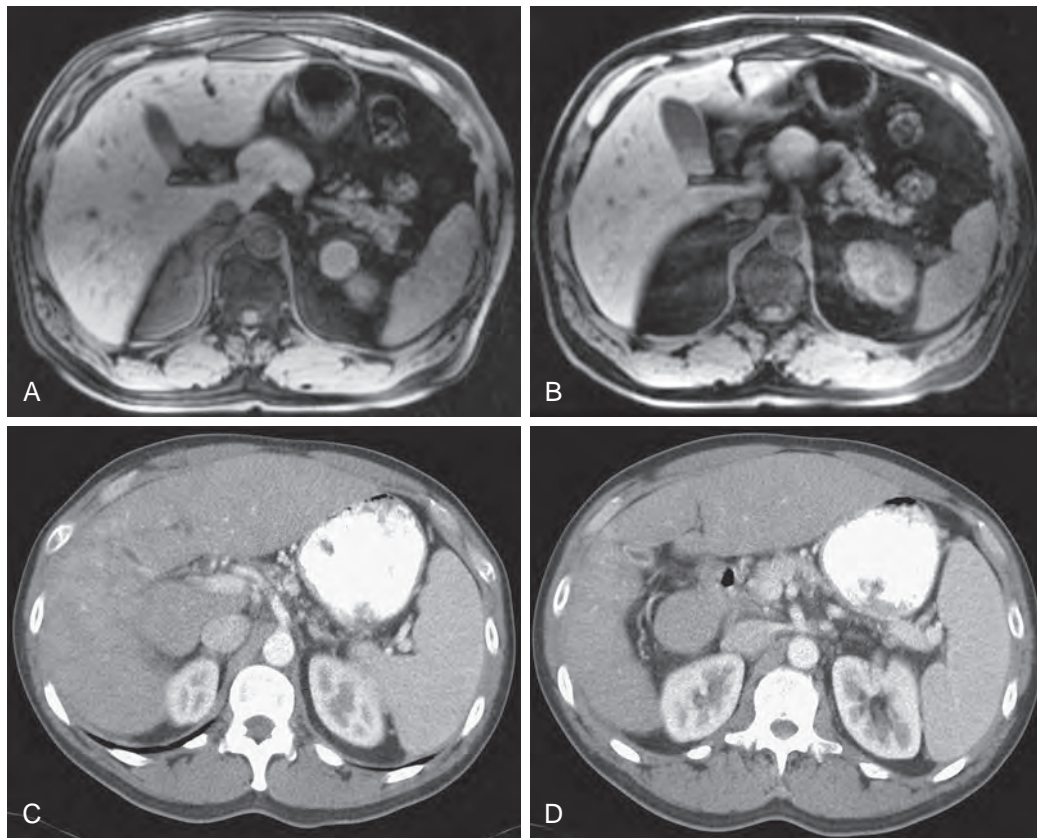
Papillary and caudate process pseudomass. A and B. The T1-weighted fat suppression images reveal medial extension of the papillary process near the head of the pancreas. Notice that the signal characteristics of this mass are similar to the remainder of the liver and not to the pancreas. C and D. Contrast-enhanced CT scan of the upper abdomen in a different patient reveals inferior extension of an enlarged caudate process mimicking a mass anterior and lateral to the inferior vena cava.
